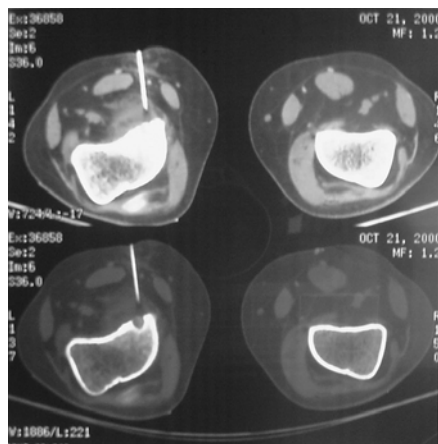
Needle navigation with CT scan.
